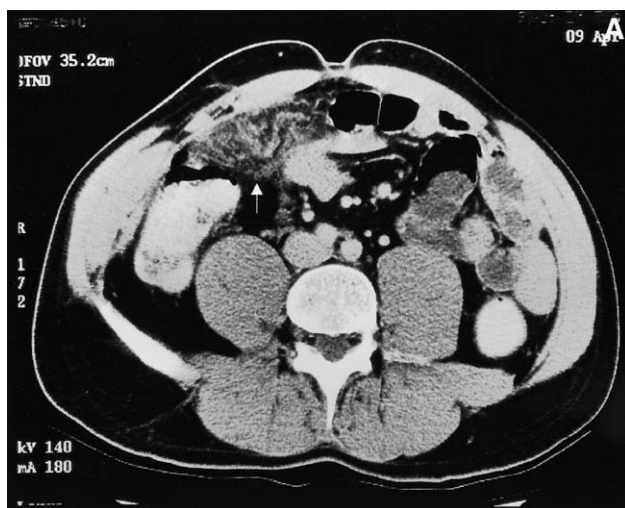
Abdominal CT scan: A) fat interspersed with hyperattenuating streaks (arrow), and B) ovoid tissue mass in the paraumbilical region (arrows), two typical findings of idiopathic segmental infarction of the greater omentum.
